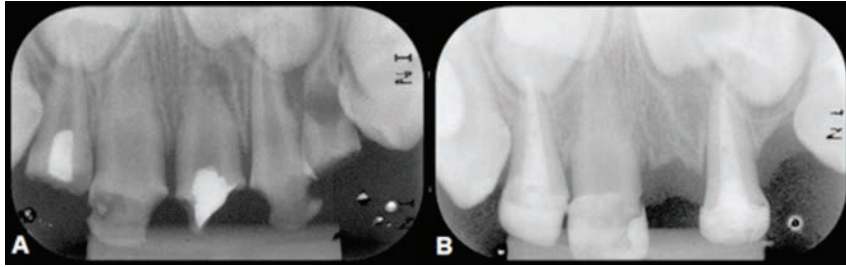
Radiographic performance of Pa3. A) Initial periapical radiograph evidencing primary maxillary left lateral incisor. B) Radiograph monitoring of primary maxillary left lateral incisor after 17 months of treatment.
